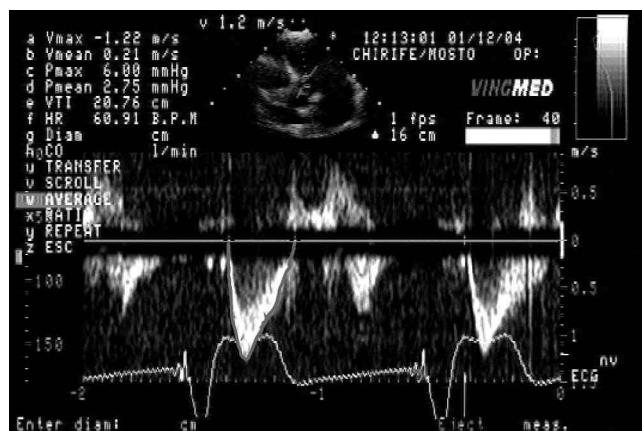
Determination of the aortic velocity-time-integral (VTI) from the Doppler echocardiography.
